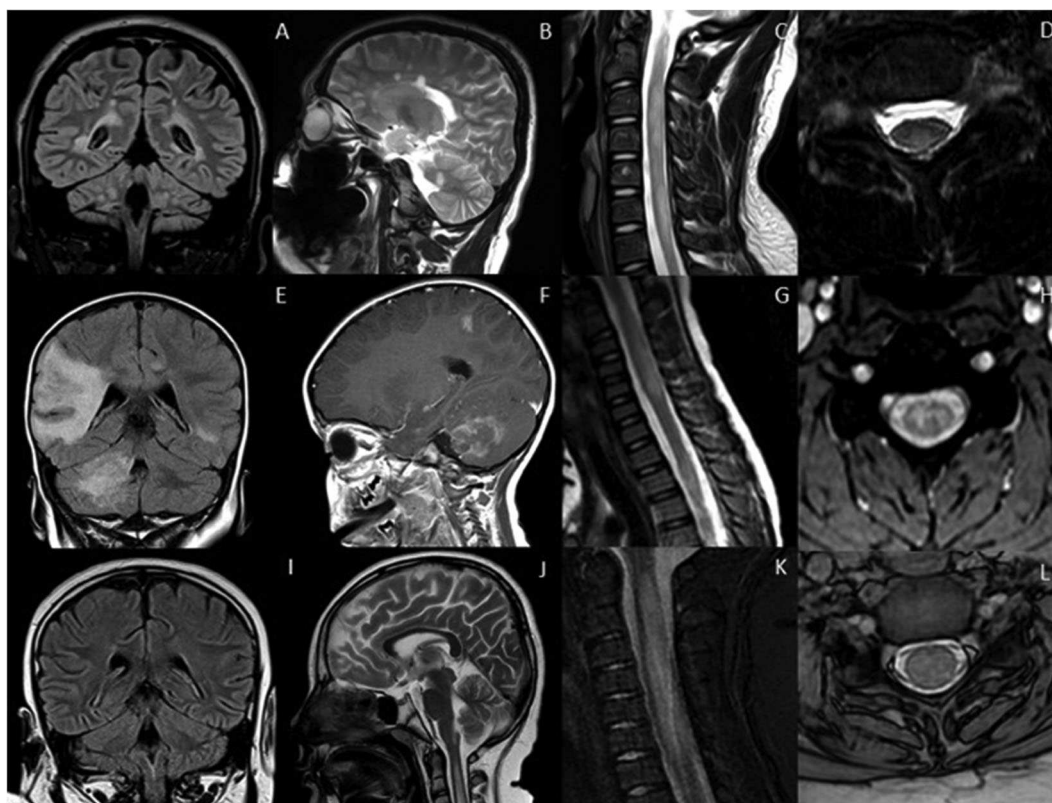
Typical appearances of RDS in children. MS—top row (A–D) Juxtacortical, periventricular and infratentorial brain lesions are readily appreciated on coronal T2-FLAIR (A) and sagittal T2-weighted images (B). In the spine there are short segment eccentric lesions appreciated on sagittal and axial T2-weighted images (C,D, respectively). MOG-AD—middle row (E–H) Large confluent lesions with ill-defined enhancement are demonstrated within the brain on coronal T2-FLAIR (E) and contrast-enhanced sagittal T1-weighted images (F). In the spine, there are lesions involving gray and white matter on sagittal and axial T2-weighted images (G,H, respectively). AQP4-NMOSD—bottom row (I–L) Brain lesions are present in areas of AQP4 expressivity. For example, in this case there is involvement of the area postrema on coronal T2-FLAIR (I) and sagittal T2-weighted images (J). A lesion is also present in the upper spinal cord. In the spine there is longitudinally extensive transverse myelitis on sagittal and axial T2-weighted images (K,L, respectively).
